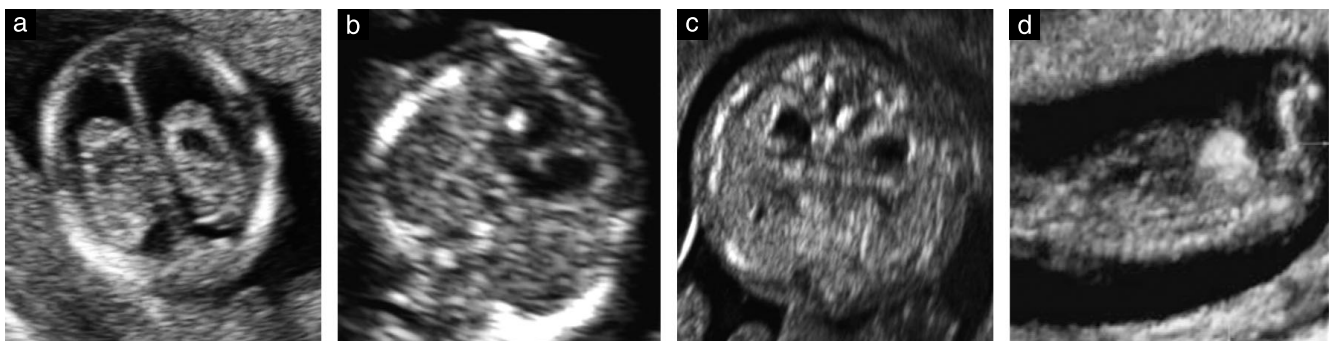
Ultrasound images demonstrating choroid plexus cyst (a), intracardiac echogenic focus (b), hydronephrosis (c) and hyperechogenic bowel (d) at 12 weeks of gestation.
